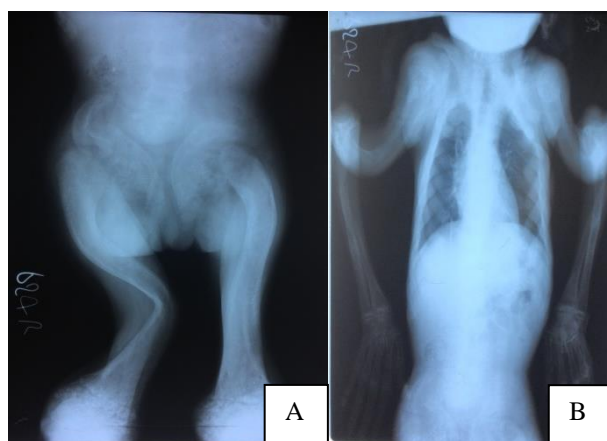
X-ray (A) pelvis with bilateral femur and knee joint and; (B) chest AP with bilateral upper limb AP-view.
